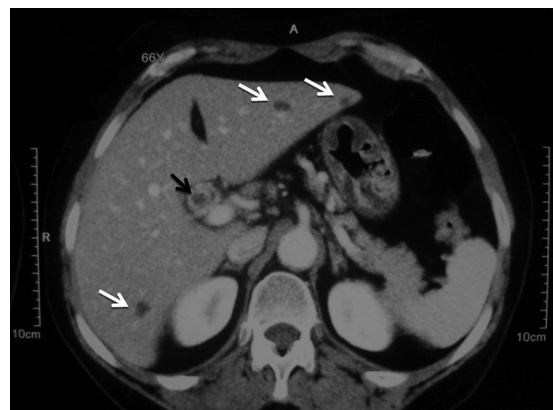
Abdominal computed tomography scan showed three small cysts (white arrows) and dilated common bile duct (black arrow).
